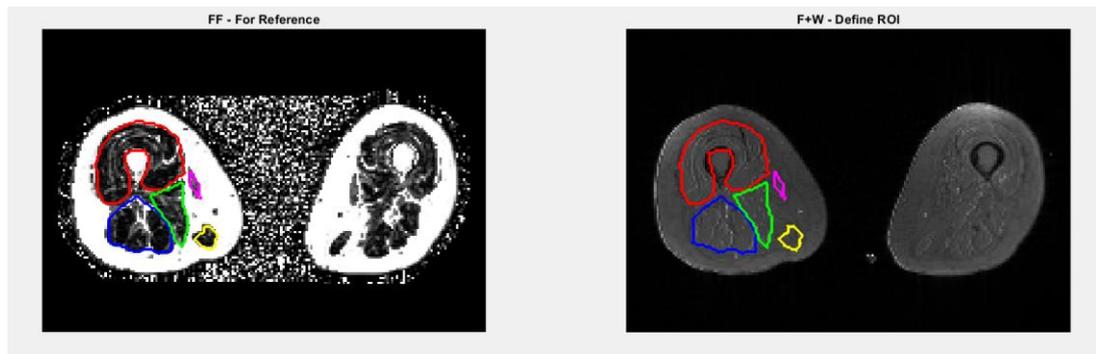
Muscles selected on MRI scans and divided into: quadriceps (red), hamstrings (blue) and “other muscles” (green, yellow and pink) on MATLAB for CSA and fat fraction analysis
